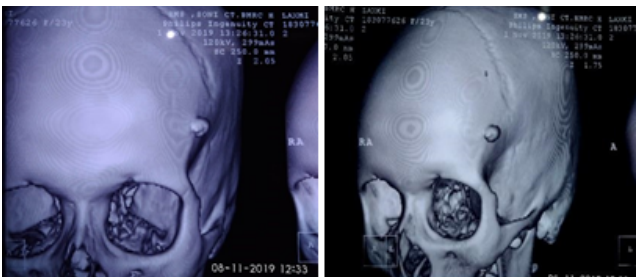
CT Head showing tumor characteristics
